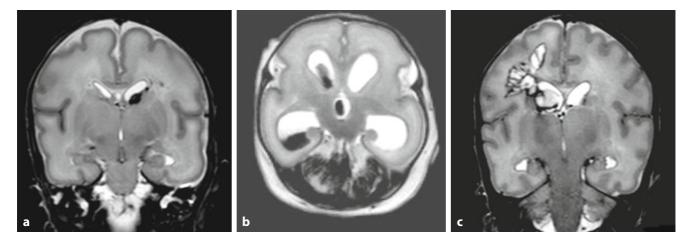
MRI (T2 weighted sequence) of the three preterm infants shown in Fig. 138.2; IVH associated with petechial hemorrhage in the left periventricular white matter (a); besides large IVH, bilateral cerebellar hemorrhages are seen (b); IVH and PHI, similar to cUS (c)
